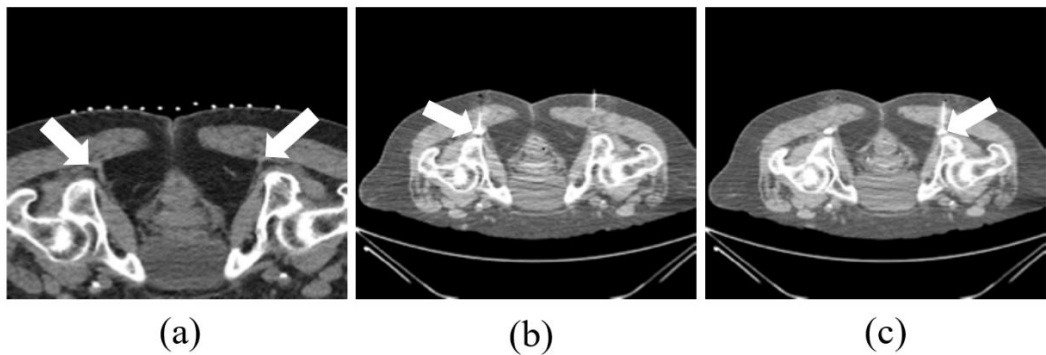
CT Acquisitions Portraying Pulsed Radiofrequency Ablation of the Pudendal Nerve. (a) Planning CT image demonstrates the isodense right pudendal nerve located posterior to an adjacent blood vessel; (b) Axial CT shows ablative changes following probe placement within Alcock’s canal targeting the left pudendal nerve; (c) Axial CT shows similar ablative changes with the probe introduced into Alcock’s canal targeting the right pudendal nerve.
